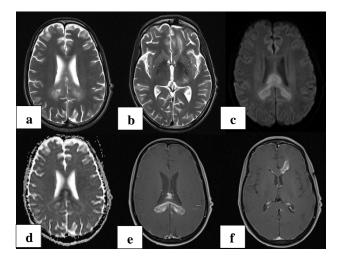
47-year recently diagnosed HIV positive male presented with generalized weakness; (a) - (d) on T2W images heterogeneously hyperintense geographical lesion in periventricular region extending to bilateral parietal hemispheres via splenium of corpus callosum with restricted diffusion on DWI. Post contrast images reveal heterogeneous and predominantly peripheral enhancement.
